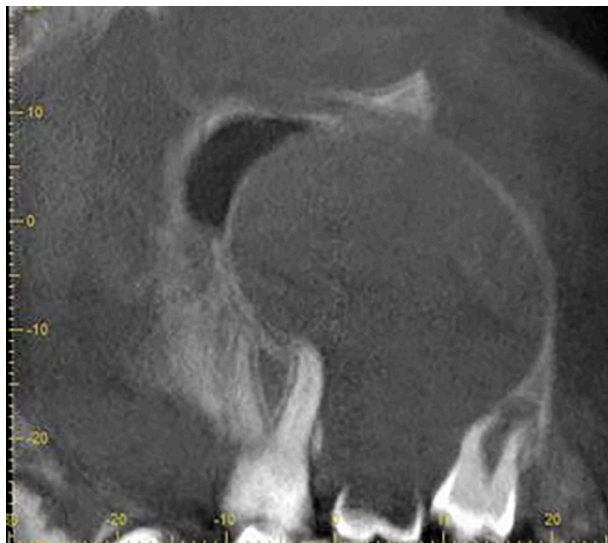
Sagittal CBCT scan view demonstrating a corticated cyst extending superiorly towards the orbital floor and medially towards the inferior meatus
